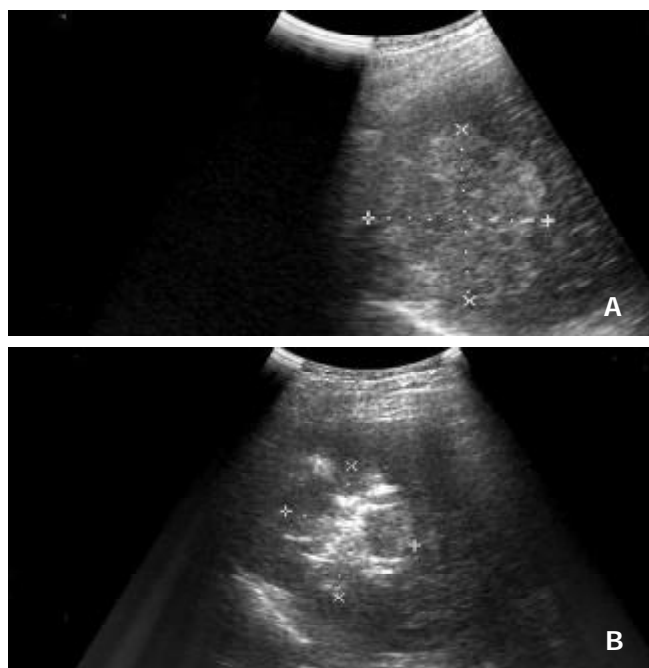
(A) Intercostal oblique sonogram shows a 5.7cm diameter nodular HCC in segment 8. (B) The RF electrode has been placed in the lesion, and the electrode tip is recognizable as an echogenic area in the tumor. Sonogram obtained after several minutes of energy deposition shows a hyperechoic patch around the electrode tip.
